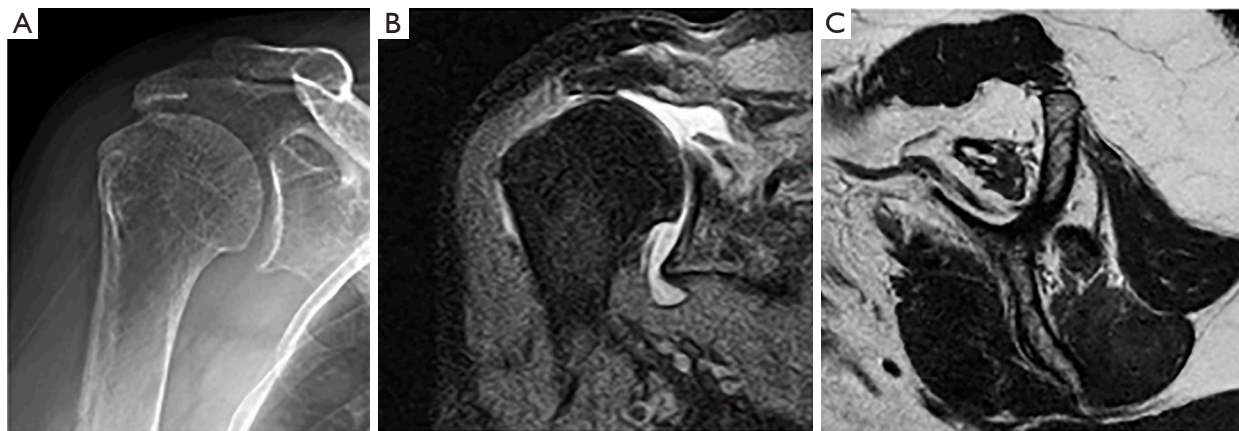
Radiologic assessment showing proximal humeral migration, decreased acromiohumeral distance, and minimal arthritic changes at the glenohumeral joint (A), T2-weighted MRI in coronal plane showing massive rotator cuff tear retracted at the glenoid level (B) and T1-weighted MRI in sagittal plane showing stage III fatty infiltration of the rotator cuff muscle (C).
